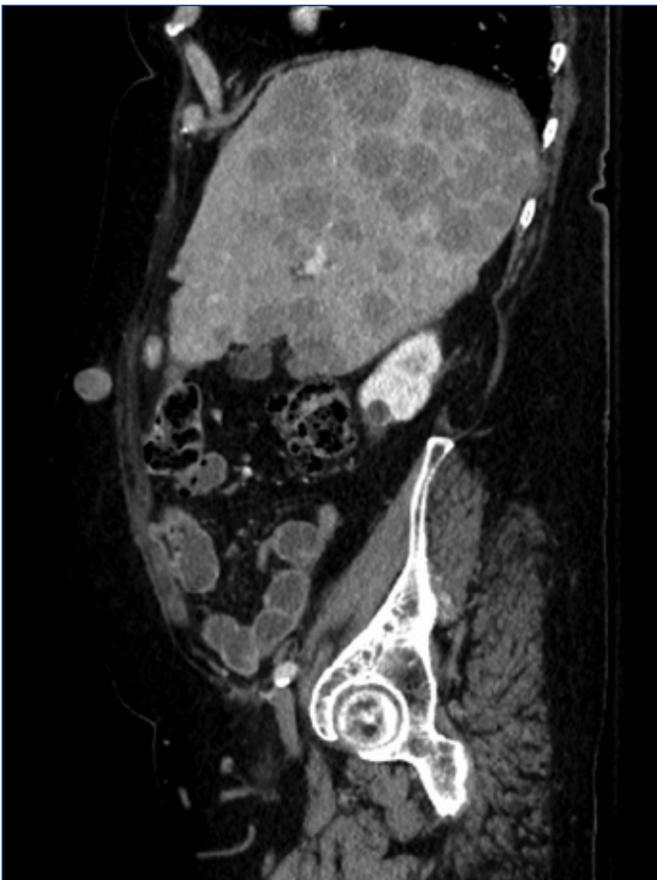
Sagittal CT Abdomen/Pelvis image of SMJ nodule and metastatic disease
